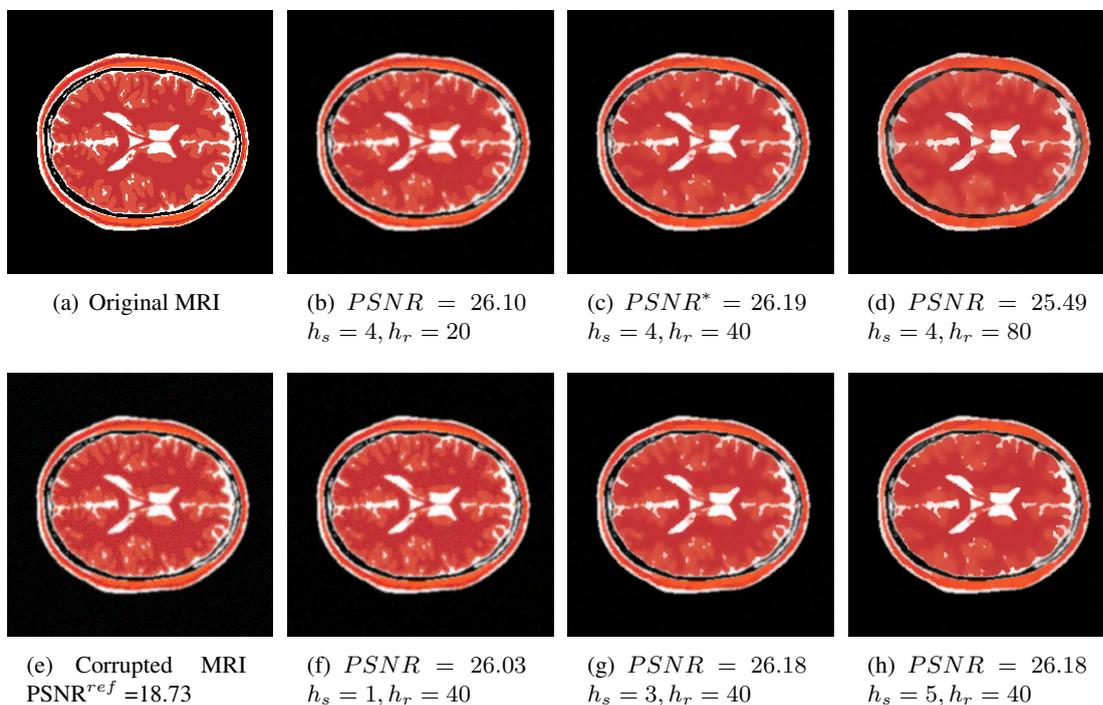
Mean Shift filtering results for corrupted MRI according to different bandwidth parameters. (a) is the original MRI data (e) is corrupted data with $\mathbf{B}[63, 1]$; The reference PSNR is computed by corrupted image and original image; (b),(c) and (d) are filtered results obtained from the fixed $h_s=2$ but different h_r along the range $[1, 255]$; the PSNR is computed by filtered image and original image; (c) is the optimal mean shift filtered result with optimal PSNR equal to 26.19dB; (f),(g) and (h) are filtered results obtained from the fixed $h_r=80$ but different h_s along the range $[1, 5]$.
